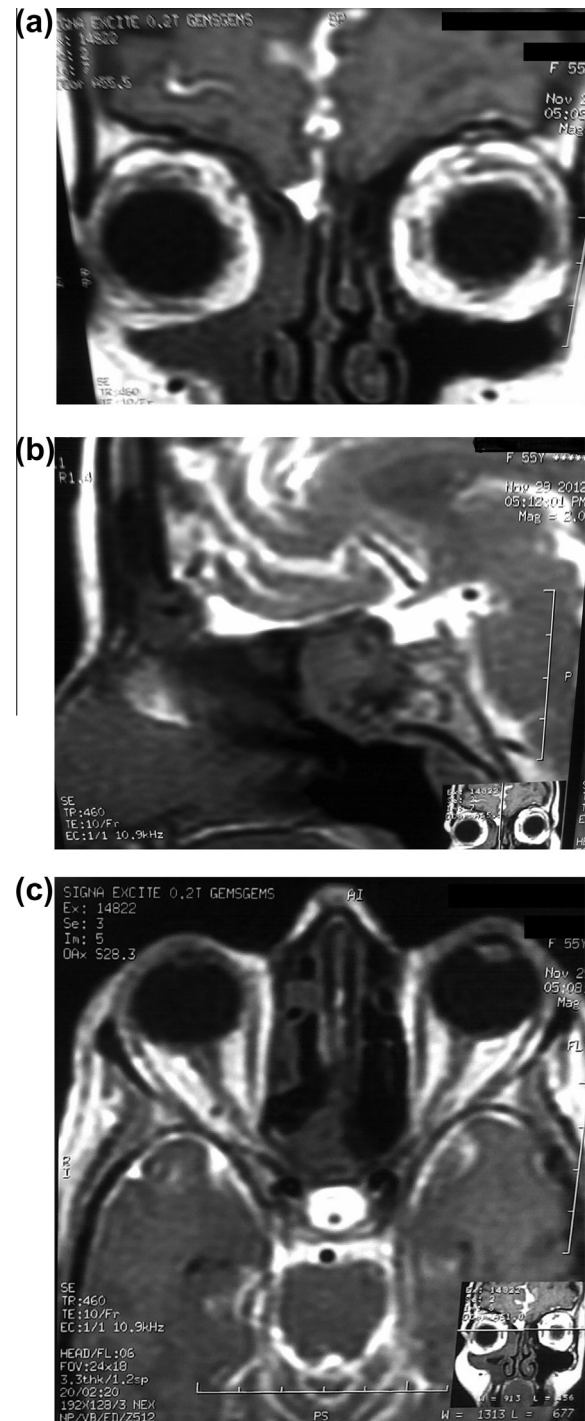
CSF rhinorrhea following head trauma in a 55-year-old female. (a) Coronal T1-weighted intra-thecal gadolinium enhanced MR cisternogram reveals contrast leak into the right ethmoid air cells through a defect in the right aspect of cribriform plate. (b, c) Sagittal and axial T1 weighted contrast enhanced cisternogram reveal the site of the bony defect in the sagittal plane and contrast flow into the right ethmoid sinus from the enhanced subarachnoid space.
